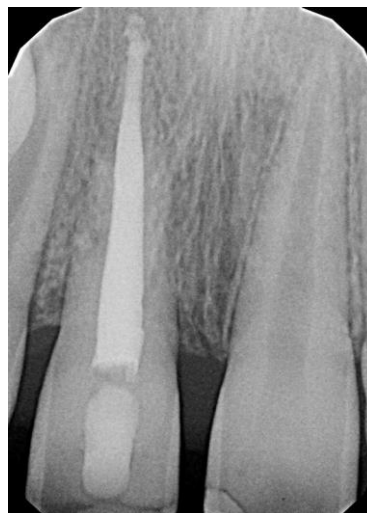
Intraoral periapical radiograph 6 months post-operative
